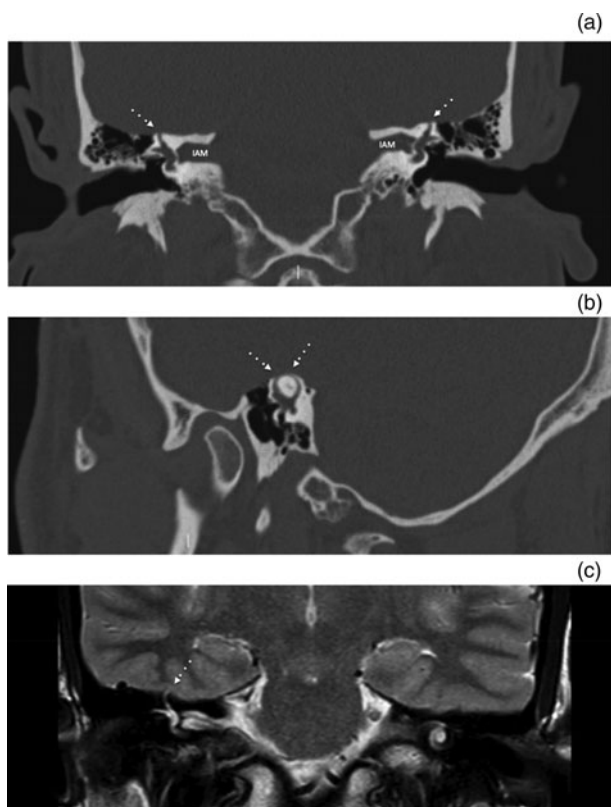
Coronal high-resolution computed tomography scans at the level of the internal auditory meatus (IAM) in a patient with bilateral superior semicircular canal dehiscence (dotted arrows) (a), and reconstruction on an oblique sagittal plane showing the extent of the dehiscence (dotted arrows) (b). Although less utilised for superior semicircular canal dehiscence diagnostics, coronal T2-weighted magnetic resonance imaging of the IAM shows protrusion of the right superior semicircular canal deep in the middle fossa and temporal lobe (dotted arrow) in a patient with superior semicircular canal dehiscence (c).
